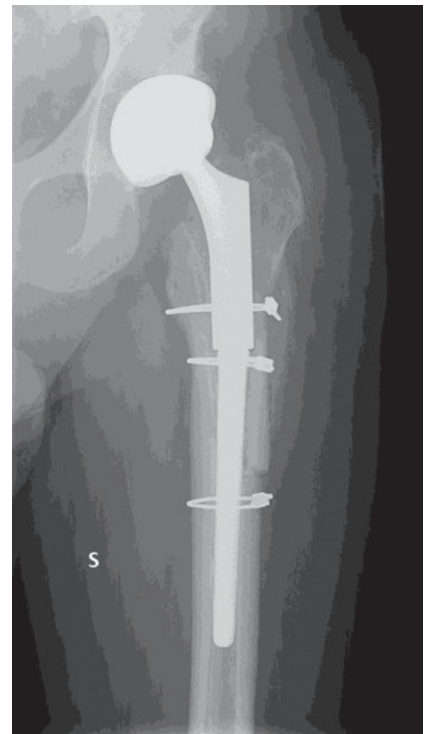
Case 1. Left hip AP view post-operative radiographs showing implant revision
